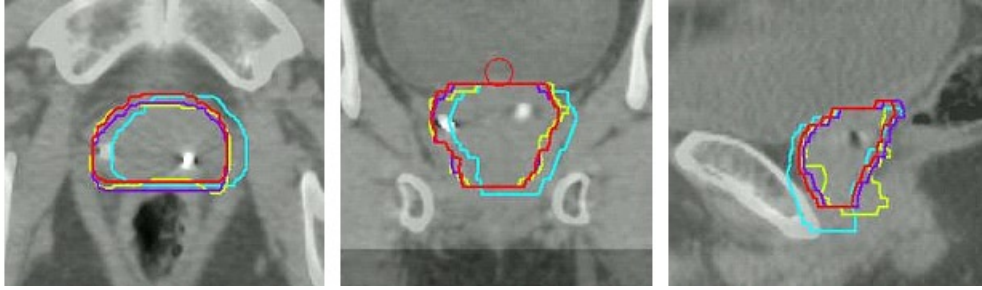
Prostate contours from different registration methods in (a) transverse, (b) coronal, and (c) sagittal views. Prostate_ROT_NC is shown in blue, Prostate_ROT_C in red, Prostate_Contour_T in purple, and Prostate_CBCT in yellow.
